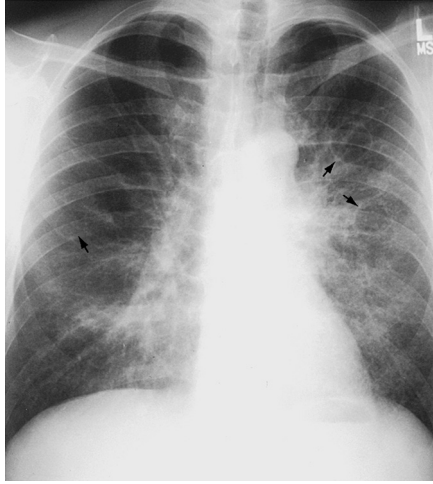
Posteroanterior chest radiograph of an HIV-seropositive patient with *Pneumocystis pneumonia* showing bilateral, predominantly perihilar granular opacities and three pneumatoceles (arrows). Pneumatoceles may predispose patients to pneumothorax. (From Mason RJ, et al. Murray and Nadel's textbook of respiratory medicine. 4th ed. Philadelphia: Saunders, 2005, Fig. 75-5. Reproduced with permission from L. Huang.)
